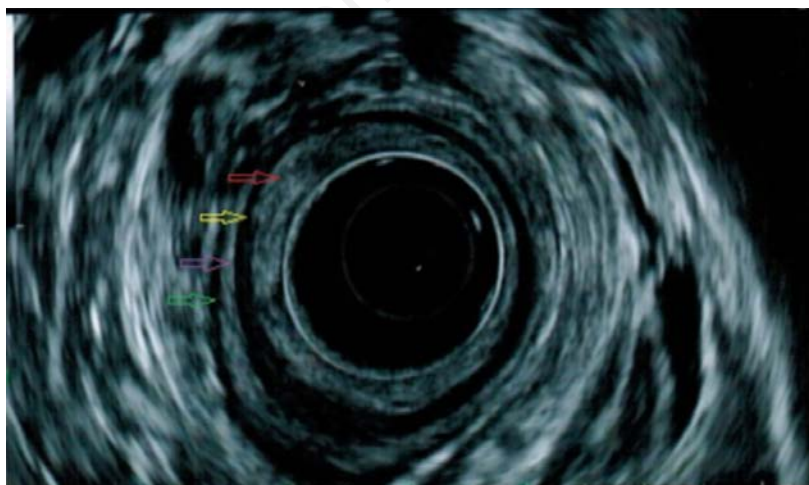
Endoscopic ultrasound (EUS) performed after the endoscopic resection of the leiomyoma revealing no residual lesion in the rectum. Mucosa (red arrow), Muscularis mucosae (yellow arrow), Submucosa (purple arrow) and Muscularis propria (green arrow).
